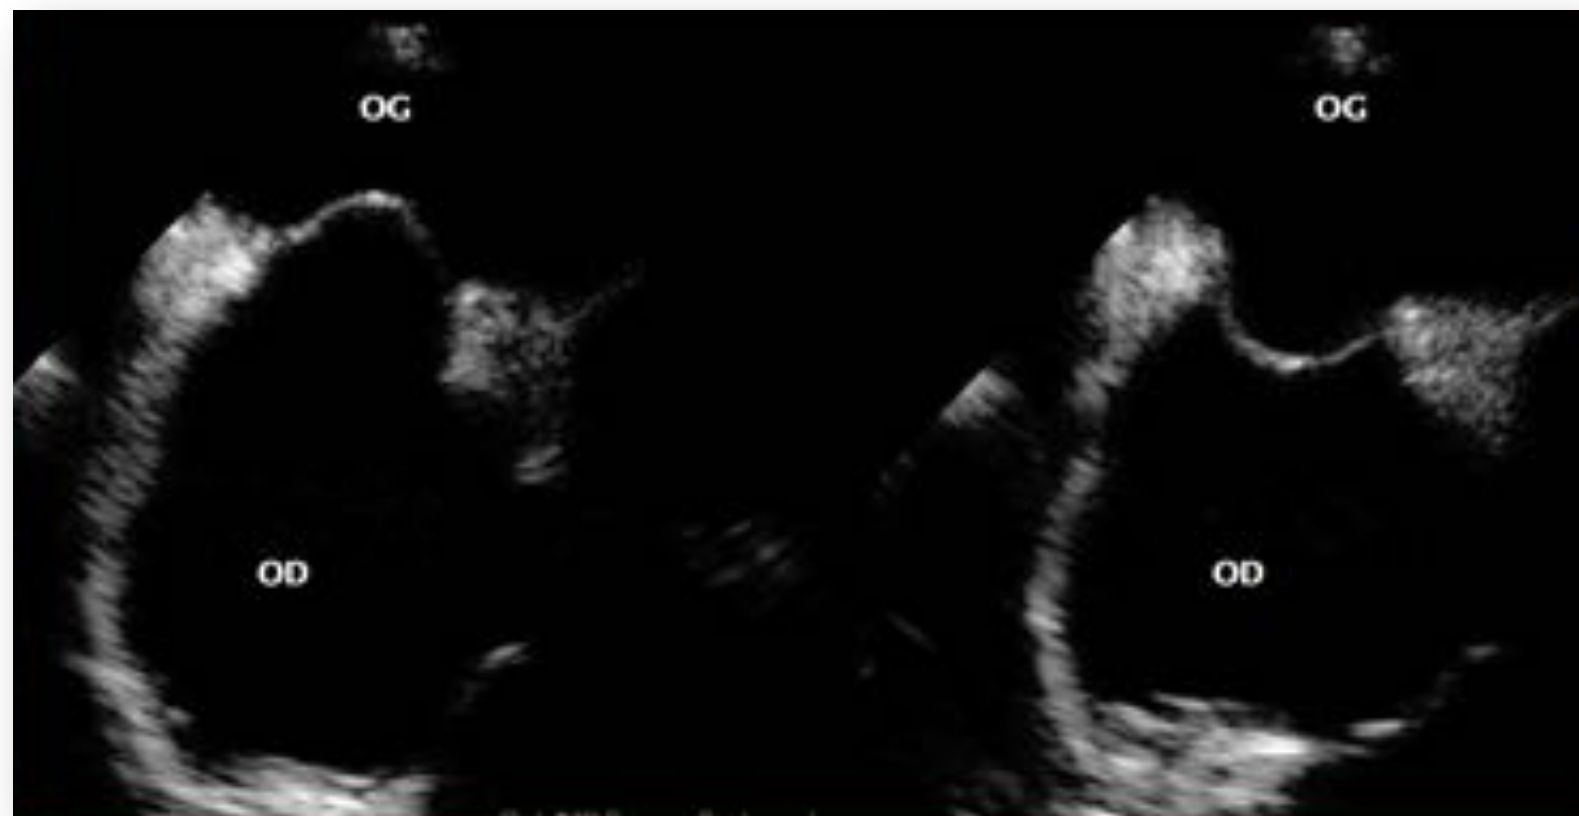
Echocardiographic four-chamber view, as well as the different bulgings of the atrial septum with aneurysm, showing the new classification of atrial septal aneurysm and how normally the atrial septum is seen in a two-dimensional depiction.
